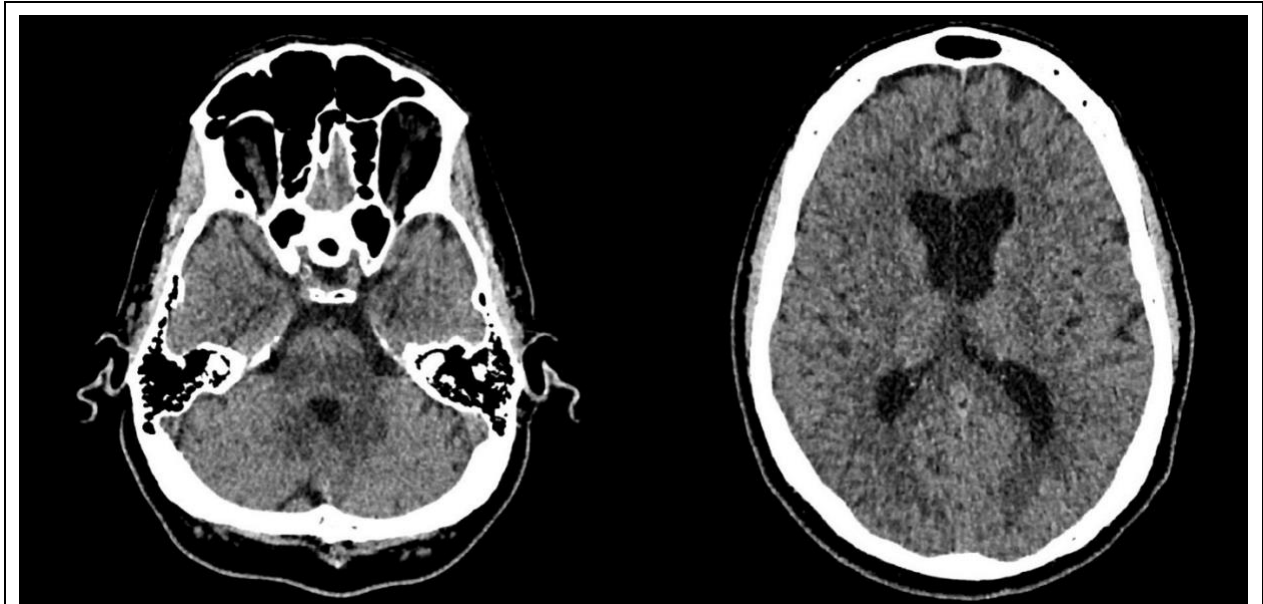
Non-contrast CT brain demonstrating normal anatomy.
